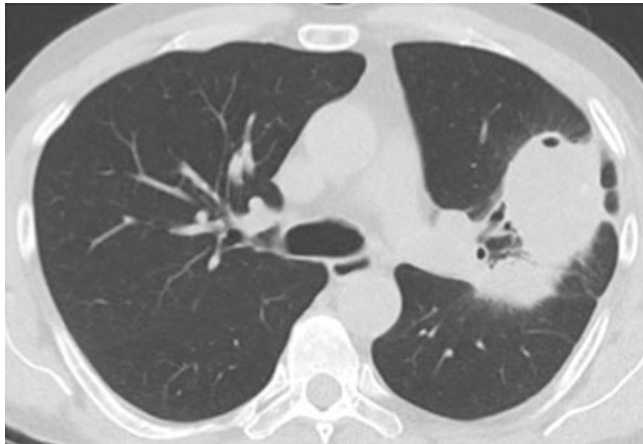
CT of the chest without contrast showing left lung with large consolidative mass in the upper lobe with cavitation in the anterior, inferior portion, and surrounding smaller nodules in bilateral lungs
